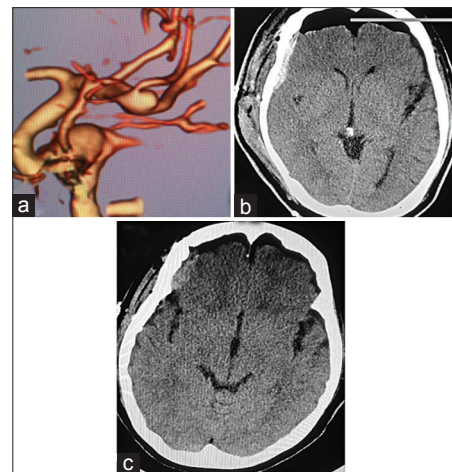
(a) Three-dimensional computed tomography angiography image of right middle cerebral artery aneurysm, (b) postoperative computed tomography head of the right middle cerebral artery clipping with large dead space and pneumocephalus, (c) follow up computed tomography head at 1 month with complete resolution of dead space and no chronic subdural hematoma/hygroma formation
